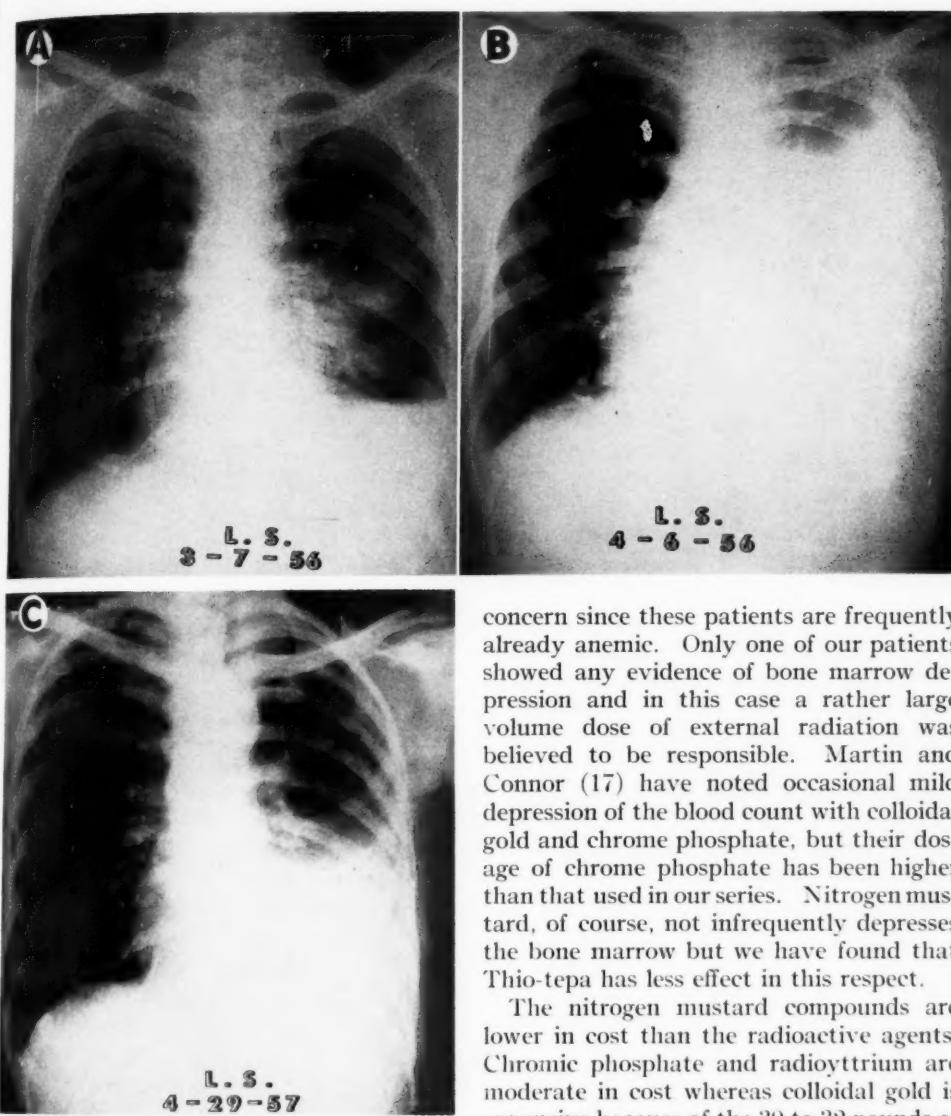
Case I. A. Chest roentgenograms made on March 7, 1956, six days after thoracentesis and instillation of chrome phosphate.
